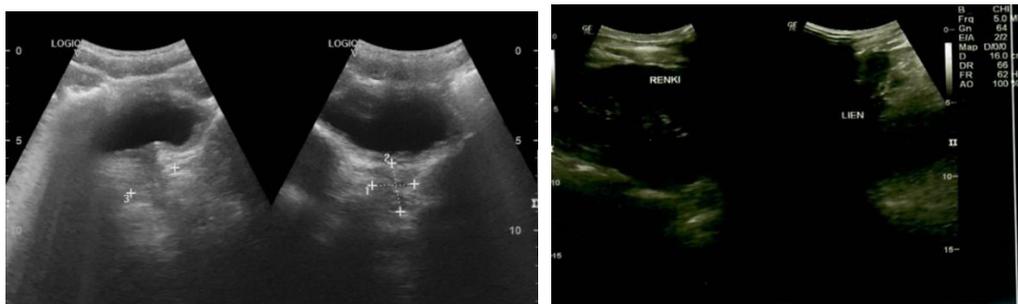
Abdominal ultrasonography of the patient.
